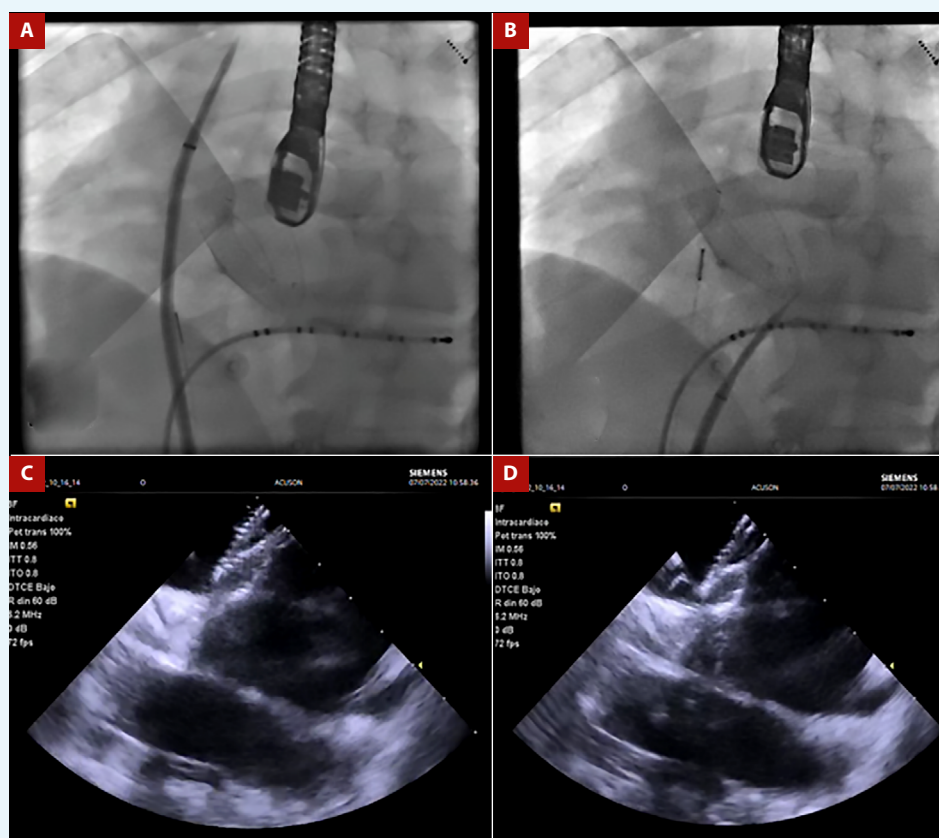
A. Fluoroscopic view in left anterior oblique projection showing the long sheath with the transeptal puncture needle positioned in the superior vena cava. B. Presence of the long sheath and the transeptal puncture needle at the posteroinferior edge of the occluder device in the remaining interatrial septum. C. Intracardiac echocardiography image showing the remaining interatrial septum in the posteroinferior region and the occluder device. D. Presence of a "tent-like" image in the remaining interatrial septum as the needle is about to pass through to the left atrium.
